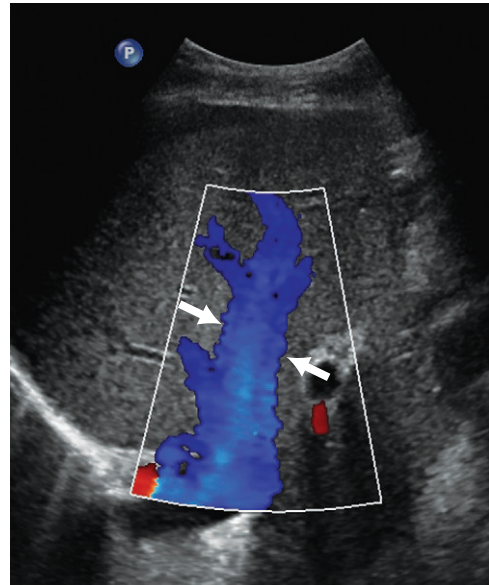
Color Doppler of a normal hepatic vein entering the inferior vena cava. The vein appears to be larger in color (arrows) than in gray scale. This is because of excess color gain.
